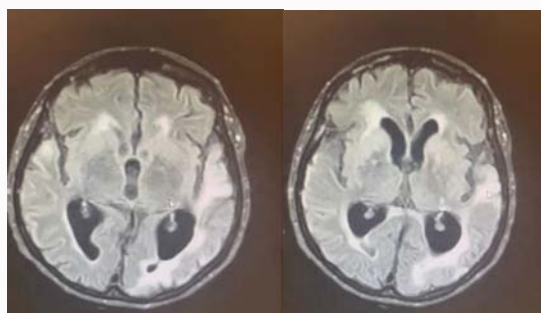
Contrast enhancement in thalamic capsular vascular lesion, left. Lentiform nucleus has hypersignal on FLAIR, hypoxic-ischemic lesion, dilatation of the ventricular system.
